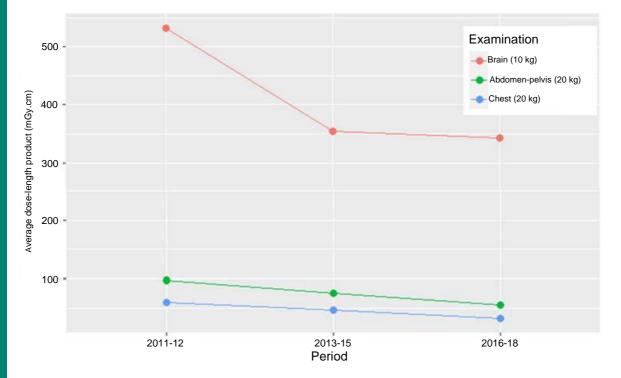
Development of dose values in computed tomography (dose length product) in children, for 3 anatomical regions (brain 10 kg, abdomen-pelvis 20 kg, and chest 20 kg) monitored as part of the DRL system
